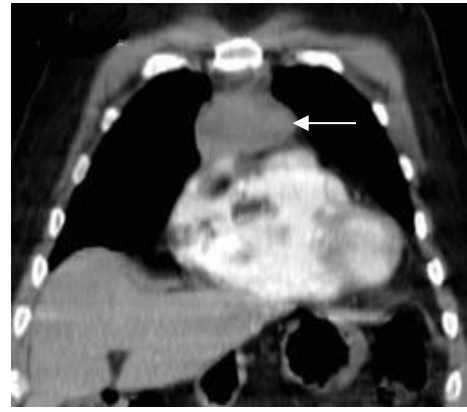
Computed tomography image of the patient showing the mass (arrow) in contact with the pericardium
